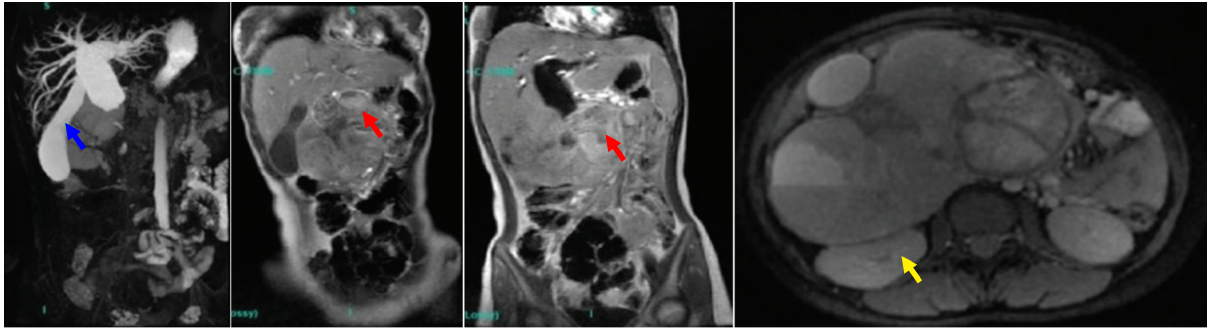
Magnetic resonance imaging (MRI) examination before surgery. Solid cystic mass (red arrows) in the pancreas compressing the right kidney (yellow arrow), dilatation of proximal and middle common bile duct, and gallbladder hydrosis (blue arrow)
